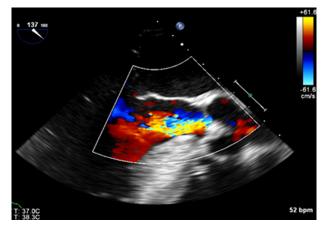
Two-dimensional TEE, midesophageal long-axis view (137°) with color Doppler, diastolic phase, demonstrating moderate AR. The vena contracta width was measured at 0.4 cm.
